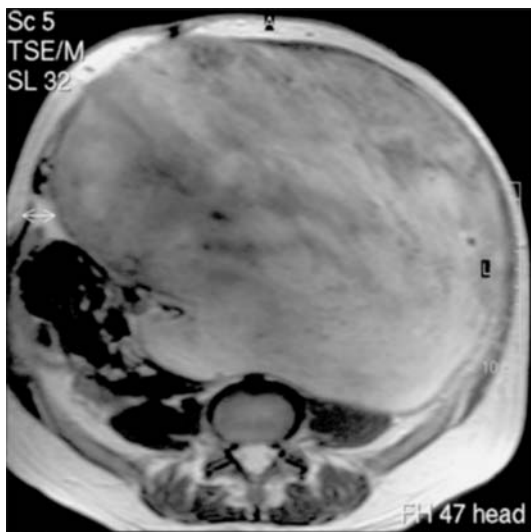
T2-weighted MRI of intra-abdominal tumour showing high (bright) signal indicative of rapid future growth.
